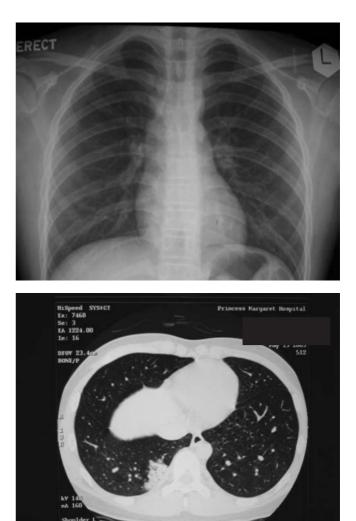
High-resolution computed tomography of thorax showing peripheral, subpleural, focal consolidation of the right lower lobe that was not evident on the admission chest radiograph.
